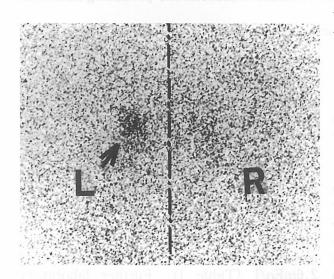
Posterior adrenal scintigraphic image from case 1 at seven days after ¹³¹I-iodocholesterol administration during dexamethasone suppression, showing the radioisotope activity of the left adrenal gland (arrow) without discernible right adrenal activity. L:left, R:right adrenal gland.
